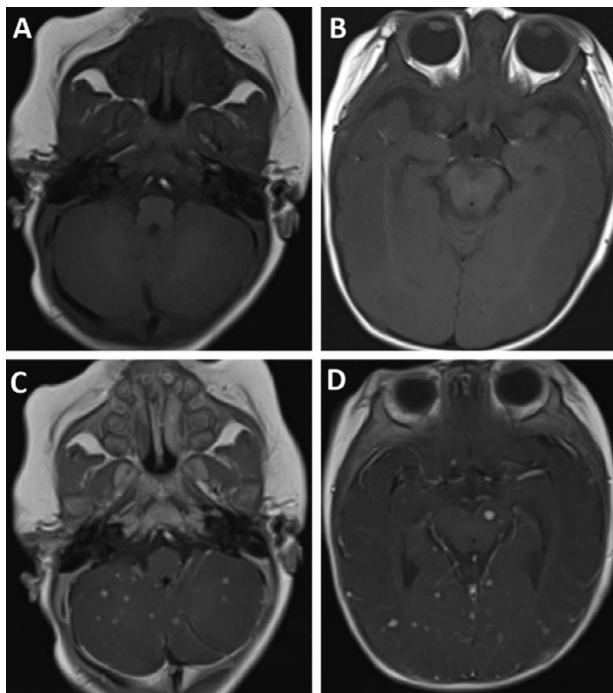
Axial T1 MRI pre-contrast (A and B) and post-contrast (C and D). Diffuse, homogeneous enhancing nodules were observed in both supratentorial and infratentorial regions. These nodules were less than 2 mm in size.
